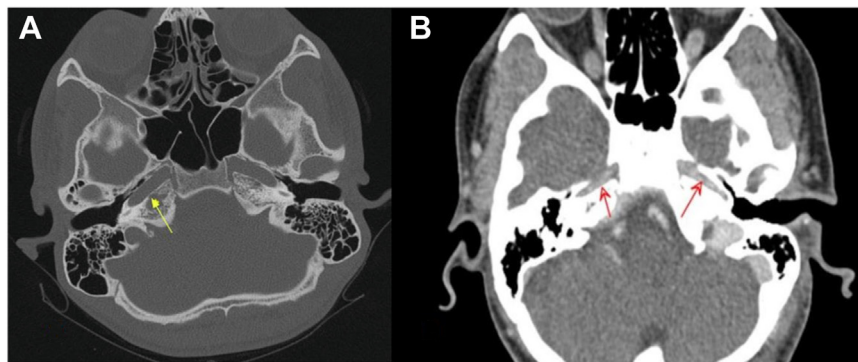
A, Axial computed tomography (CT; bone window) of a young adult man showing bilateral normal carotid canals (*yellow arrow* indicates right canal). B, Axial computed tomography angiography (CTA) of our patient showing bilateral hypoplastic carotid canals (*red arrows*).
